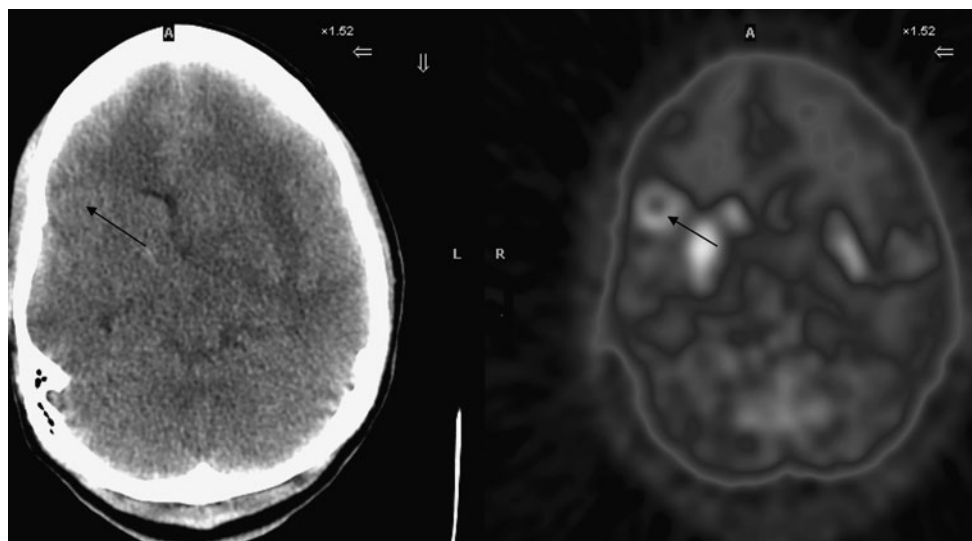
Cerebral NHL in a 30-year-old man with AIDS. Transaxial images of FDG PET-CT show a 2.0-cm lesion with intense uptake (SUV 8.0) and photopenic center in the right frontal lobe (arrows). Pathology from craniotomy suggested NHL. FDG uptake is usually
